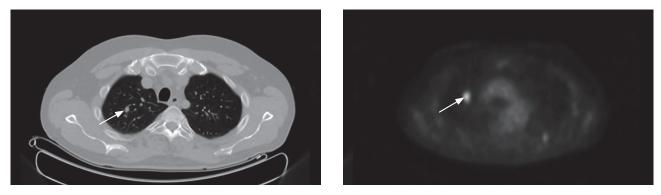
Axial thorax positron emission tomography/computed tomography image showing a pulmonary nodule (arrow) in the apical segment of the right upper lobe with hyper uptake of the 18 F-FDG, referable to secondaries.
